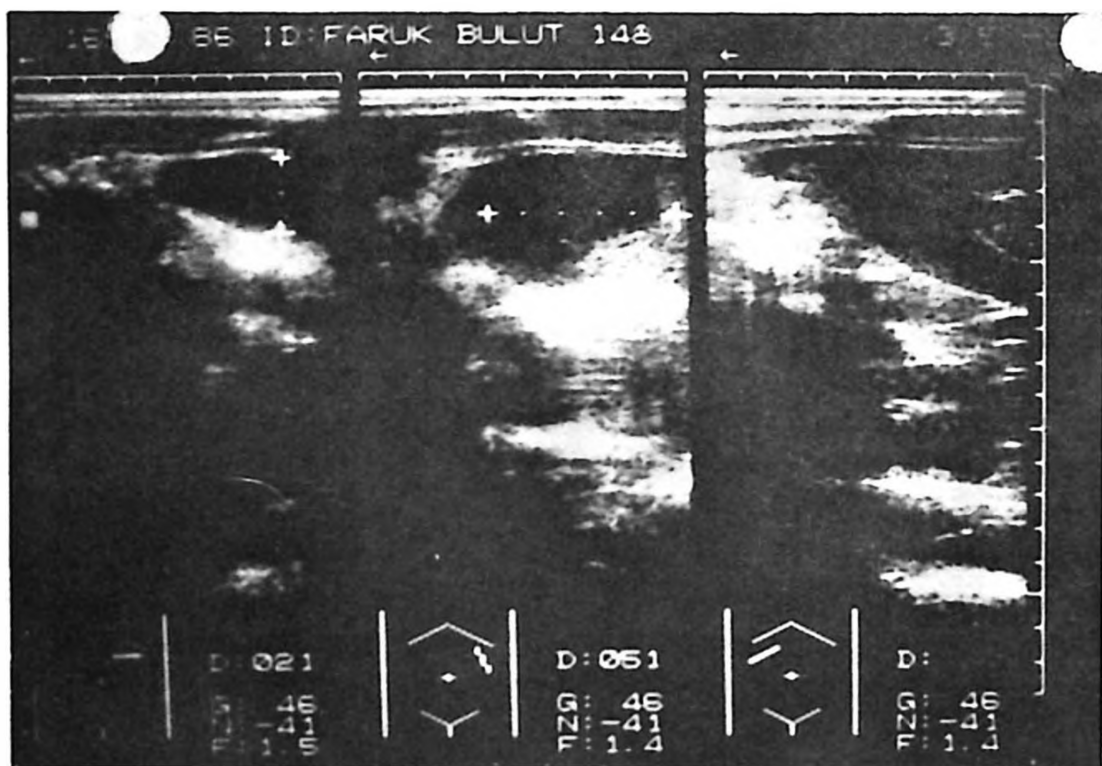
Ultrasonography of the patient indicating the abscess in the spleen.
